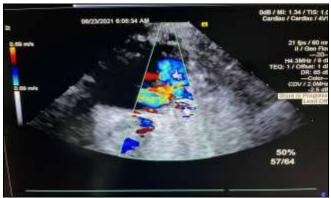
Color Doppler showing Good Flow in LPA
